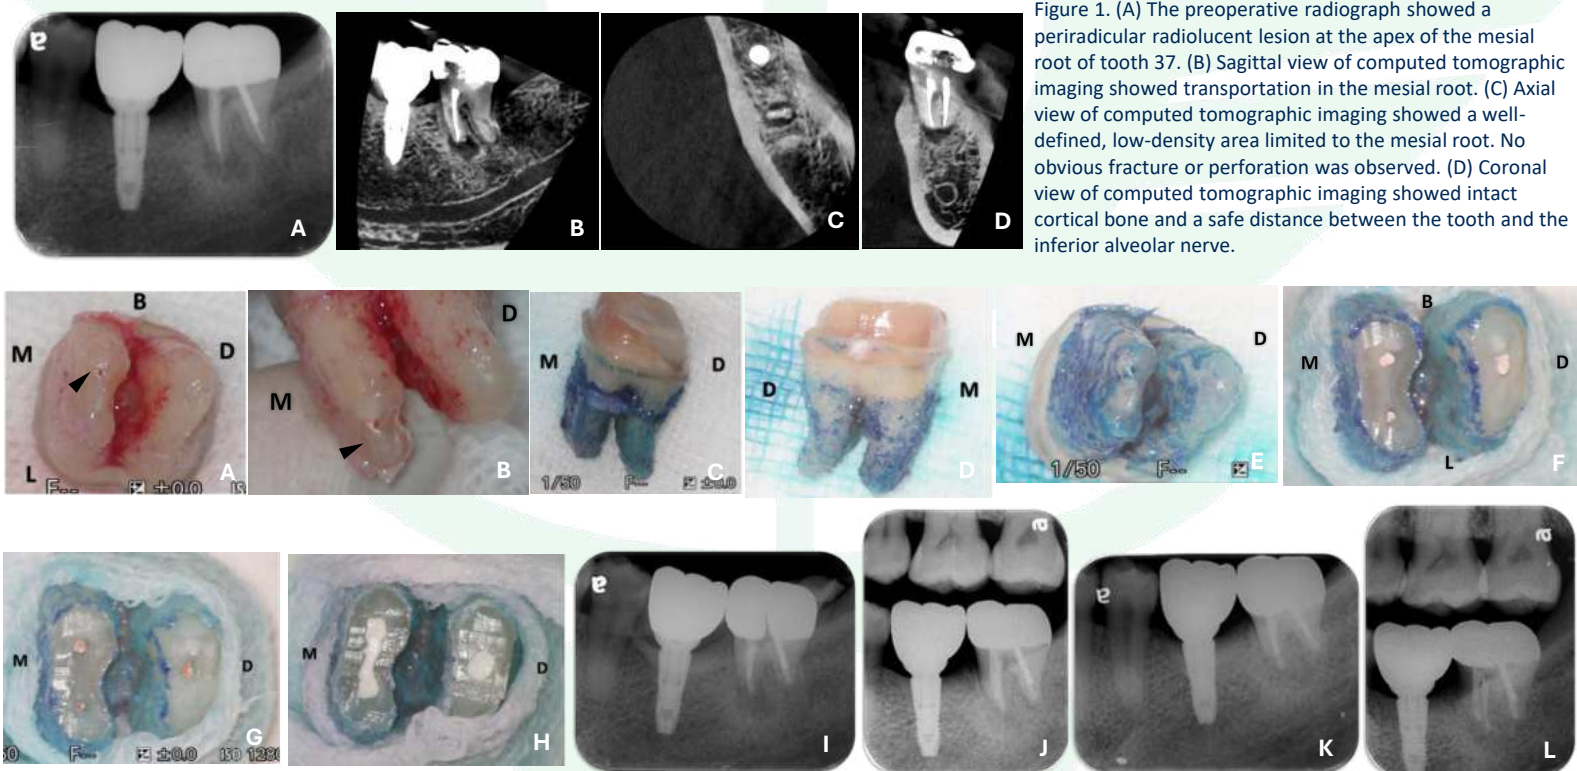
(A,B) Gutta-percha extruded beyond apical foramen of mesiobuccal root (arrow). (C, D, E) Root surface inspection. (F) Isthmus between mesiobuccal and mesiolingual canals and leakage in mesiolingual canal was noted after apicoectomy. (G, H) Root-end preparation and retrograde filling with MTA. (I) Postoperative radiograph. (J) Radiograph at 5-month recall. (K, L) Radiograph at the 12-month recall.
